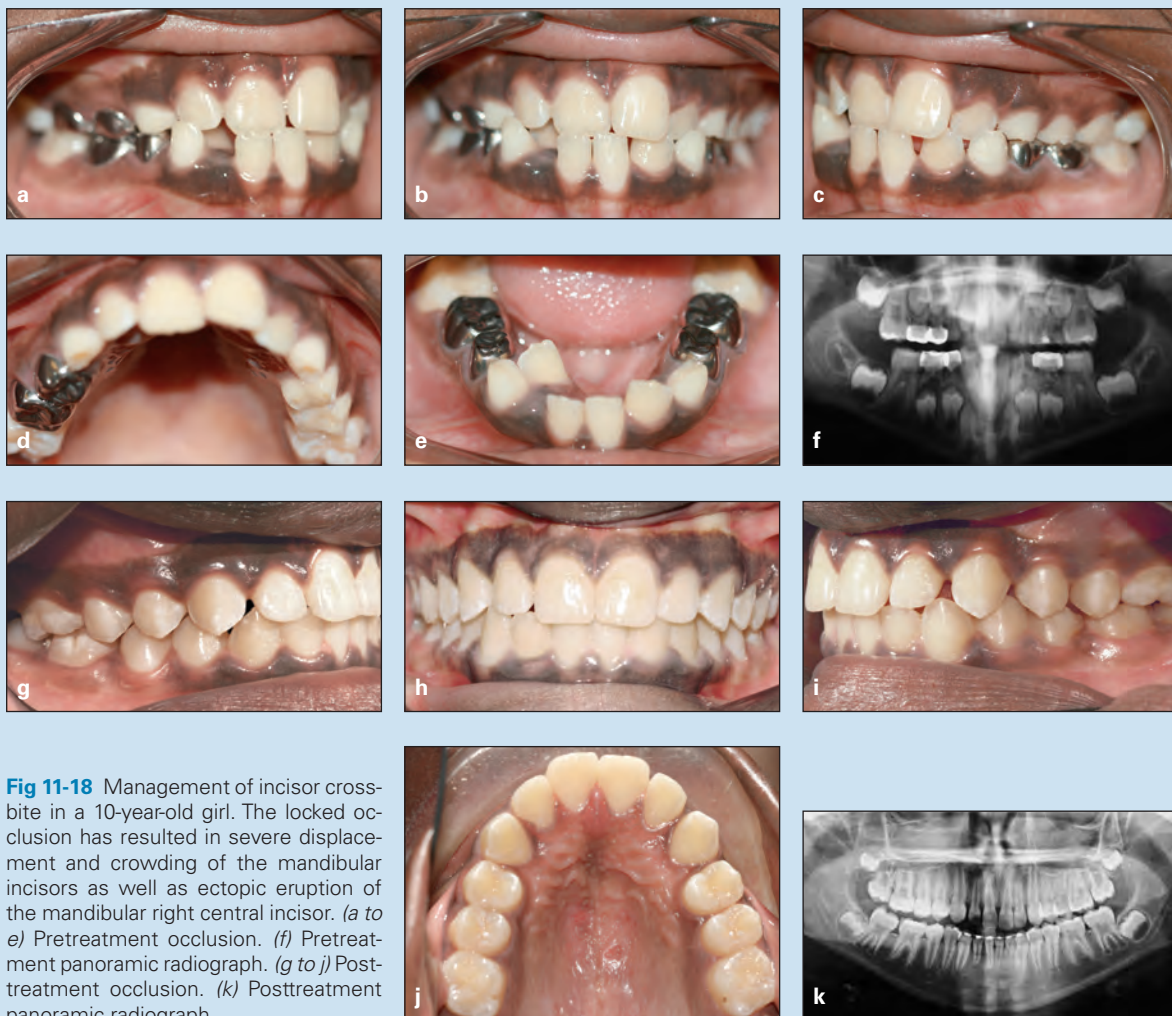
Management of incisor crossbite in a 10-year-old girl. The locked occlusion has resulted in severe displacement and crowding of the mandibular incisors as well as ectopic eruption of the mandibular right central incisor. (a to e) Pretreatment occlusion. (f) Pretreatment panoramic radiograph. (g to j) Posttreatment occlusion. (k) Posttreatment panoramic radiograph.
